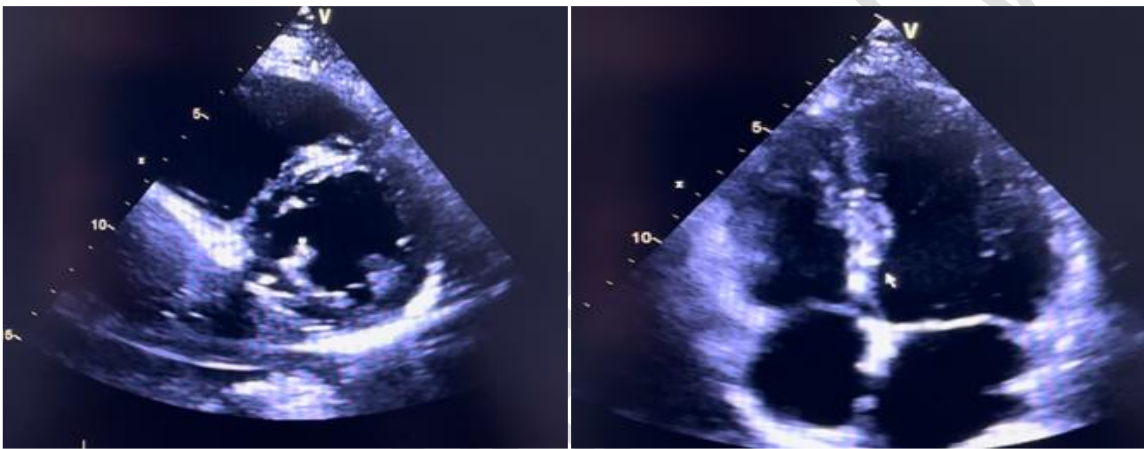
Echocardiogram revealed normal contractility of the heart and no pericardial effusion
